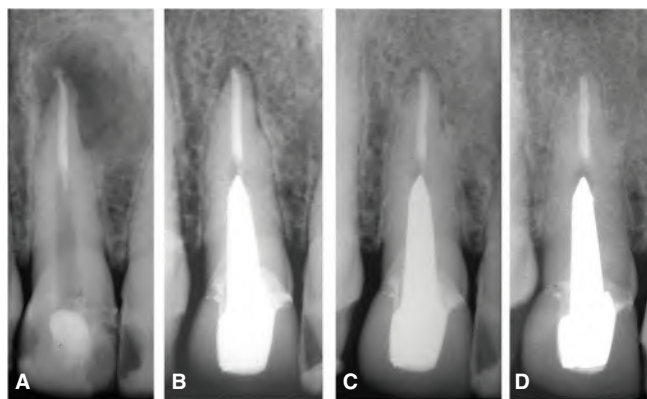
Endodontic treatment in a maxillary lateral incisor of a 32-year-old female. The patient presented with severe irradiating pain. A. Immediate postoperative radiograph showing periapical radiolucency associated with the affected tooth. B. Six-year follow-up radiograph showing marked reduction of periapical radiolucency, however, without complete resolution. The patient is asymptomatic. C. 10-year follow-up radiograph showing further reduction in size of the periapical radiolucency. The patient is still asymptomatic. D. 25-year follow-up radiograph. The periapical radiolucency has completely resolved.
